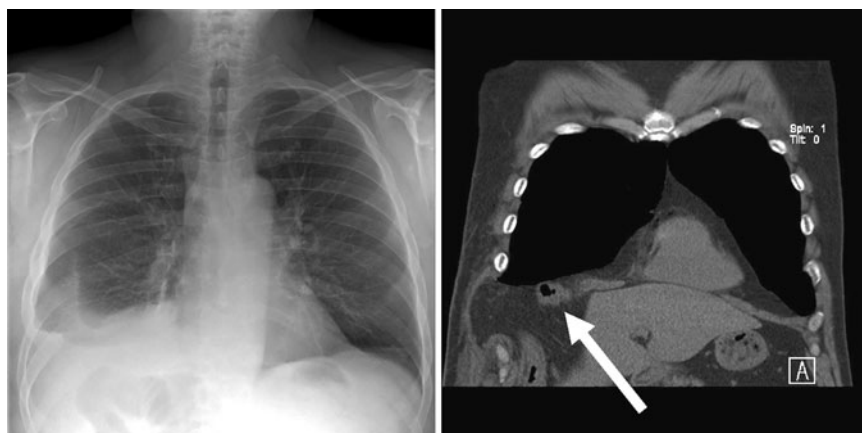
Chest X-ray and CT scan showing diaphragmatic rupture and abdominal structures in the thoracic cavity (see arrow)
